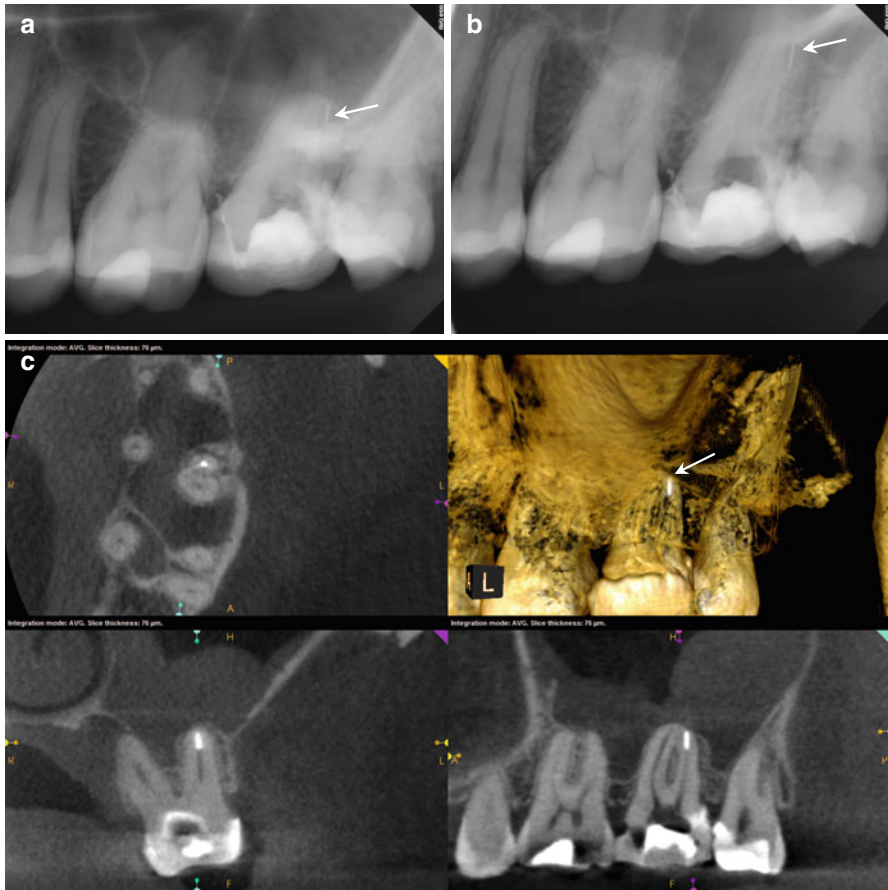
(a, b) Preoperative radiographs reveal a small, radiopaque object in the region of the DB root. (c) Preoperative CBCT scan reveals the presence of a high-density object, 2.5×0.3 mm at the apical terminus of the DB canal of tooth #15 (white arrow). This is most likely a separated instrument. There is also a marked thickening of the Schneiderian membrane evident in the coronal and sagittal views, but the patient denies any sinus symptoms. (d) The colorized sagittal section highlights the object in the DB canal, as well as insights into its possible density. Consultation with the referring office confirmed that they were unaware of the separation. The patient was informed of the object and attempts were made (unsuccessfully) to retrieve it. (e, f) Final treatment radiographs displaying the root canal obturations in the other three canal spaces and the obturation of the DB canal to the object. The patient will be recalled at appropriate intervals, and surgical revision of the DB apex will be performed as needed
